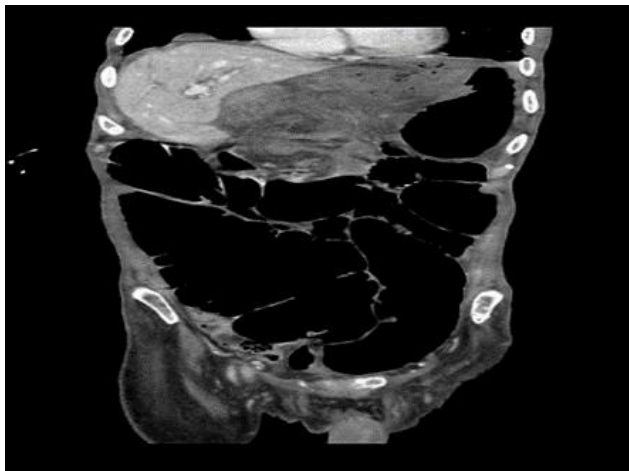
Coronal view CT
